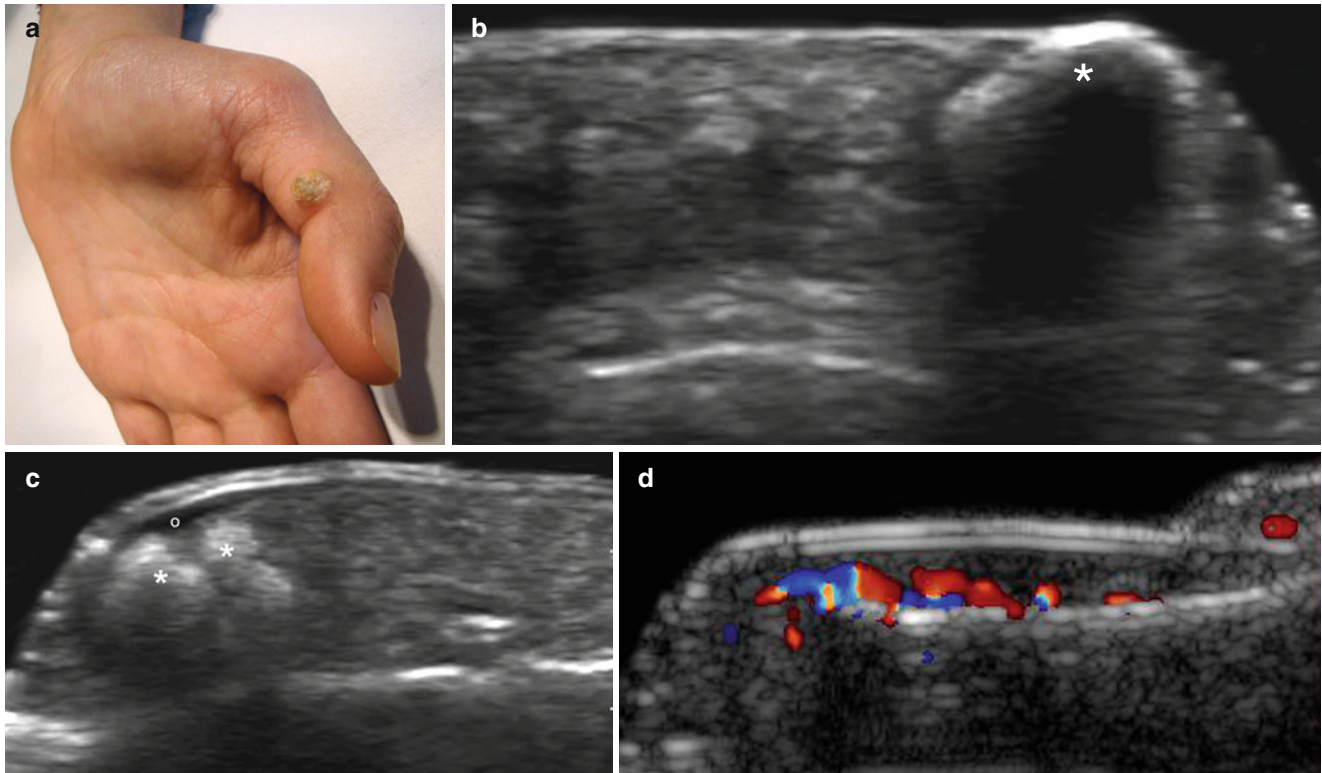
(a–d) Dermatomyositis–calcinosis. (a) Clinical image shows a whitish swelling in the radial aspect of the left thumb. (b) Grey scale ultrasound image (longitudinal view, radial aspect of the left thumb) shows a hyperechoic spot (*) in the dermis that produces a posterior acoustic shadowing artifact and corresponds to a calcium deposit.
